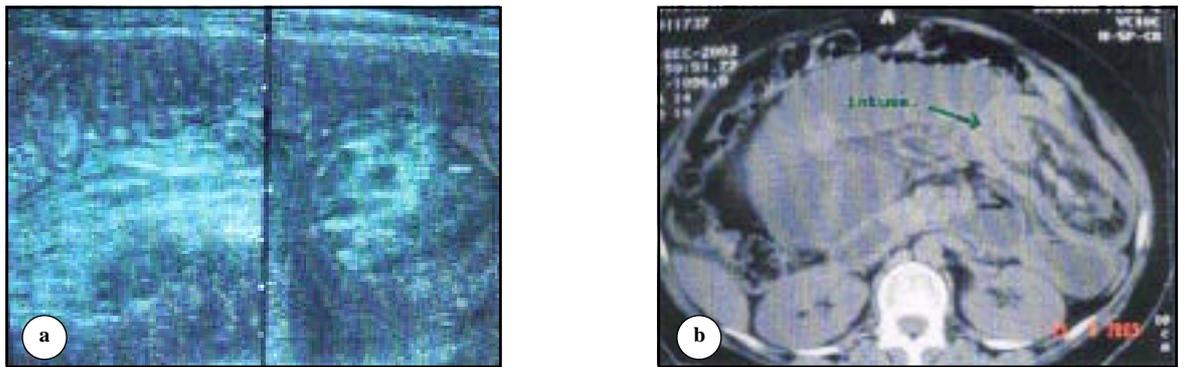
Preoperative a) ultrasound of the upper left quadrant axial and sagittal view showing high suspicion of intestinal intussusception and b) limited computerized tomography scan of the upper abdomen confirming diagnosis of small bowel intussusception.
